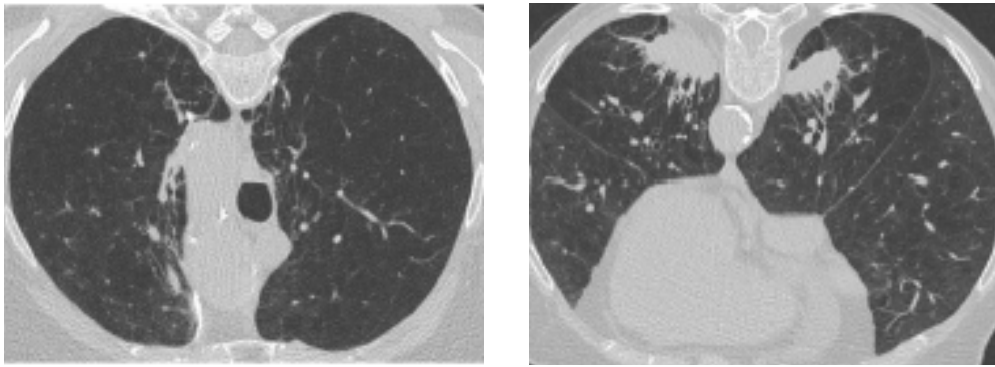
Chest computed tomography after LVRs and BTVA upper lobes (left) and right lower lobes (right)
